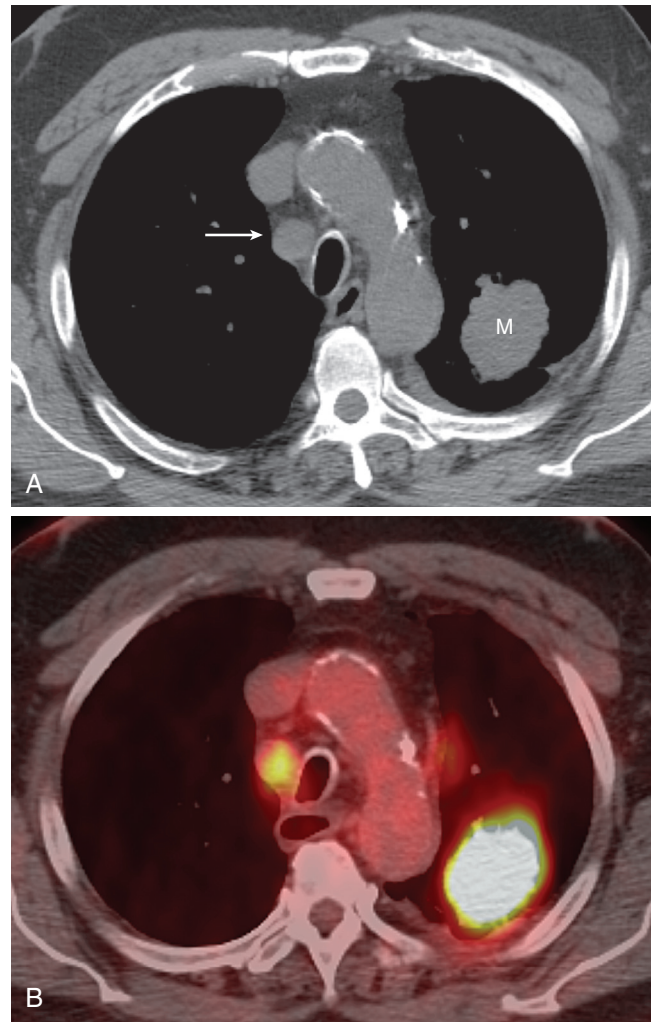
■ Non-small-cell lung cancer. A, Axial computed tomography shows left upper lobe lung malignancy (*M*) and enlarged right paratracheal node (arrow). B, Axial fused positron emission tomography–computed tomography shows increased uptake of [¹⁸F] fluorodeoxyglucose within the mass and right paratracheal lymph node consistent with a malignancy. Biopsy confirmed N3 nodal metastasis.
